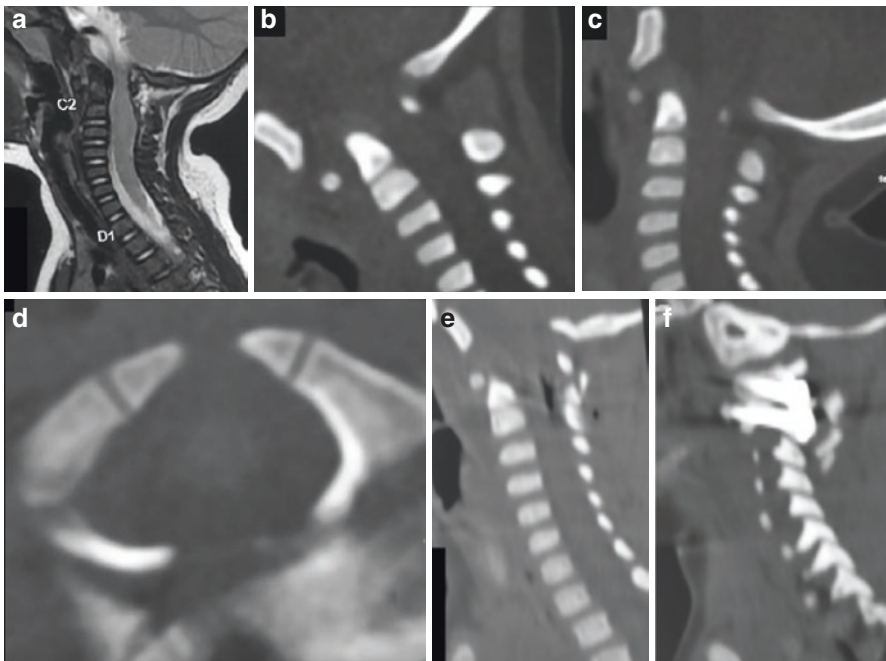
Images showing mobile atlantoaxial instability in a 3-year-old male patient. (a): T2-weighted magnetic resonance image showing atlantoaxial dislocation and cord compression opposite the odontoid process. (b) Computed tomographic (CT) scan with the head in flexion shows atlantoaxial dislocation. (c) CT scan with the head in extension position showing incomplete reduction of the dislocation. (d) Axial cut of CT scan showing bifid anterior and posterior arches of atlas. (e) Postoperative CT scan showing atlantoaxial fixation in reduced position. (f) Image showing the implants in the facets of atlas and axis
